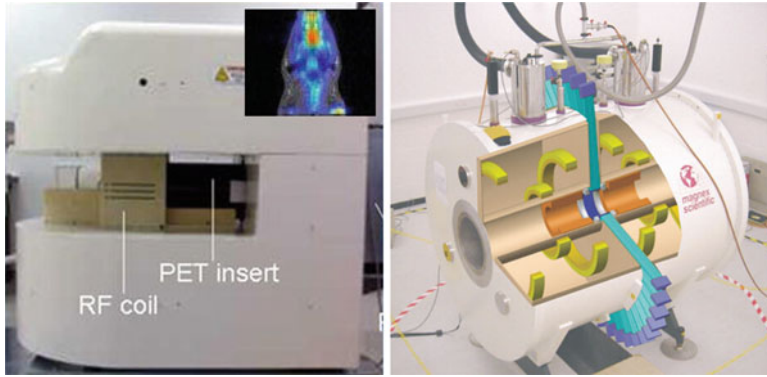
PMT-based PET/MRI using optical fibers. (a) PET/MRI using slanted light guides and optical fiber. (b) PET/MRI using split magnet and optical fiber (Reprinted from [29] and [28] with permission)
